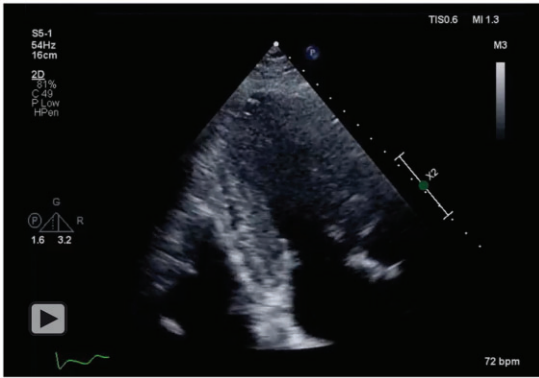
Postoperative urgent transthoracic echocardiogram. (A) Apical three-chamber view confirming presence of SAM. (B) Apical four-chamber view confirming magnitude of interventricular septum size (overestimated in A4c window).
